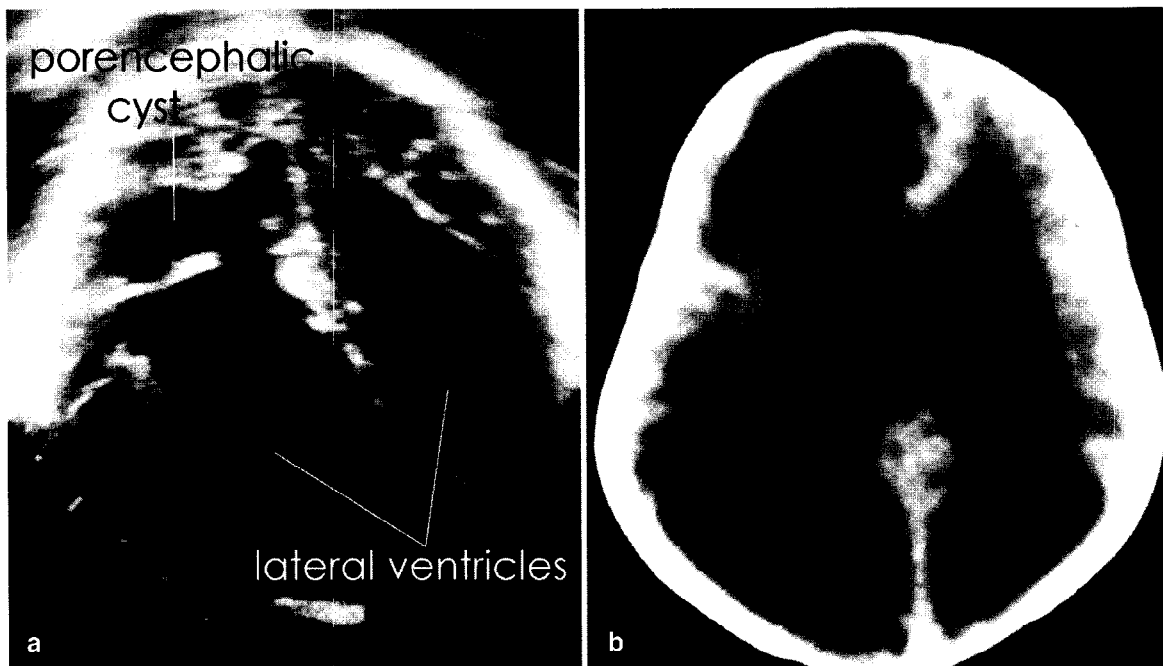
Case 9: in this fetus with asymmetric hydrocephalus, a large cyst with irregular walls, amply communicating with the cavity of one lateral ventricle, suggests encephaloclastic porencephaly. The antenatal scan (a), obtained transabdominally, is compared with an early postnatal computed tomographic image (b)
